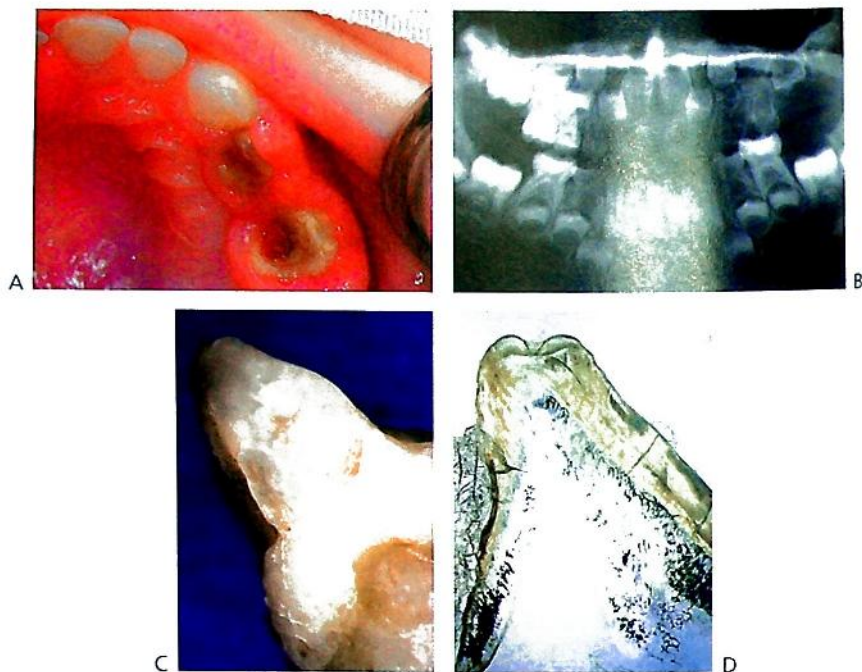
(A) Regional odontodysplasia presenting with abscessed primary molars in the maxillary left quadrant, soon after eruption. (B) The panoramic radiograph shows involvement of all the teeth in this quadrant including the permanent teeth. (C) Grossly abnormal enamel in an affected tooth and (D) the hard-tissue section demonstrates the disruption of odontogenesis. (Courtesy Dr N Pai, Sydney, Australia.)
